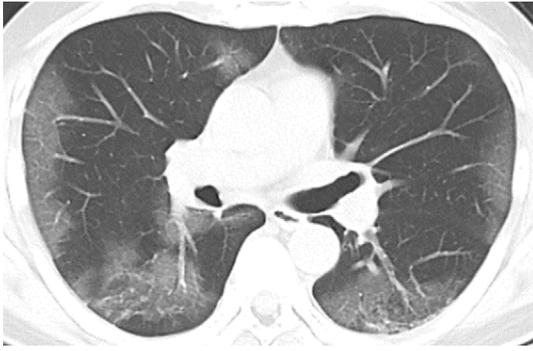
Chest CT scan on admission.
